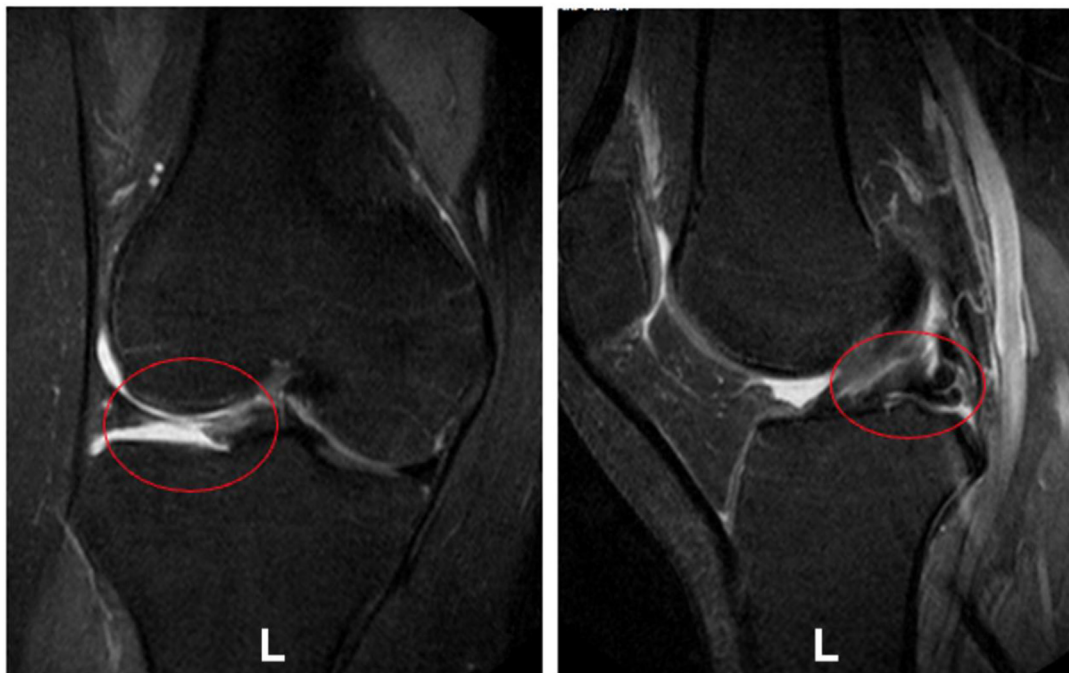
Preoperative magnetic resonance imaging of patients (left knee): A bucket-handle tear of the lateral meniscus can be seen. The MRI used the patient's left leg.
